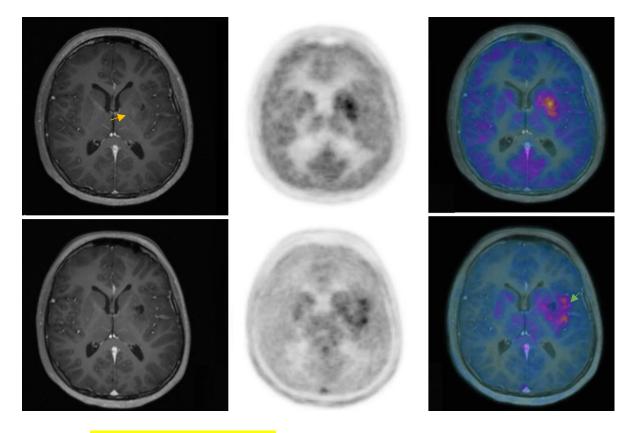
Two 18F-dihydroxyphenylalanine (F-DOPA) PET/MRI studies for a patient with anaplastic astrocytoma treated with chemoradiation. First study (top row) showed avid tumour in and around the left basal ganglia, with minimal gadolinium enhancement (yellow arrow). The second scan (bottom row) was taken 6 months later and showed lateral disease extension to the left insula (green arrow) indicating disease progression, with no significant radiological changes on MRI.
